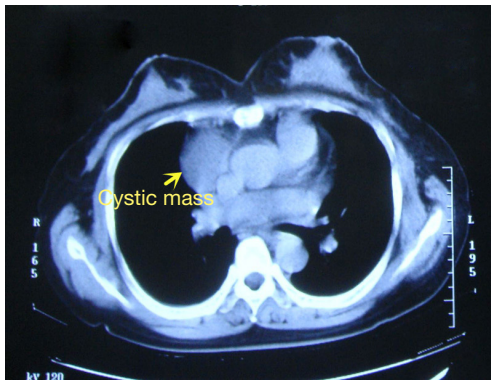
Chest CT shows the mass has homogeneous density and is located near the pericardium.
